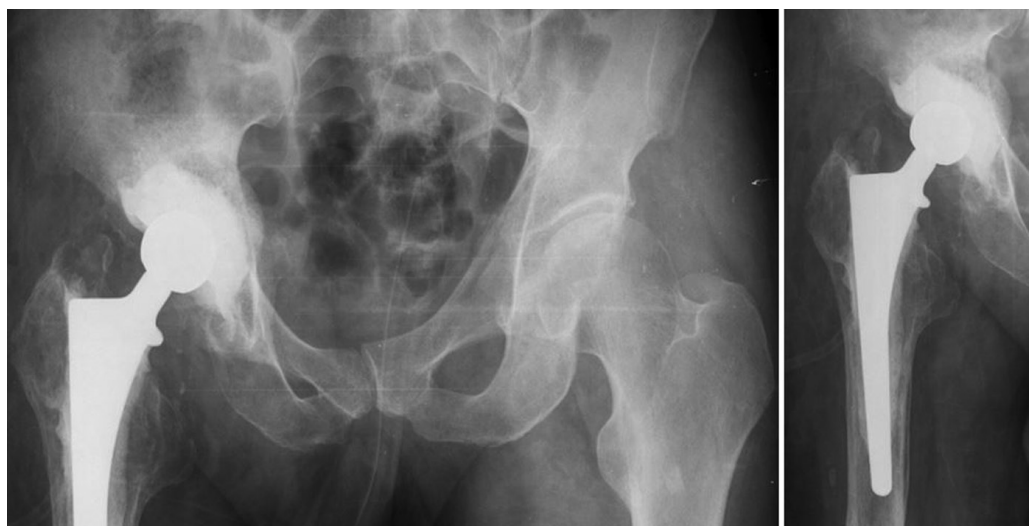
Radiographs pelvis and of the right hip joint after surgical treatment with the defect filled with allograft bone and an installed articulating antibacterial spacer
